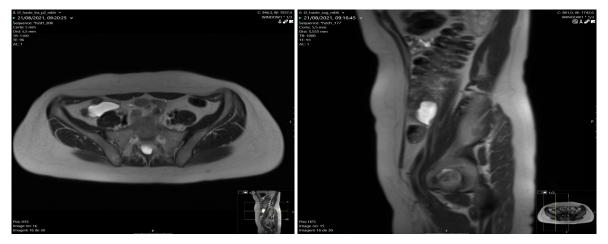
Appendicular mucocele in MRI
